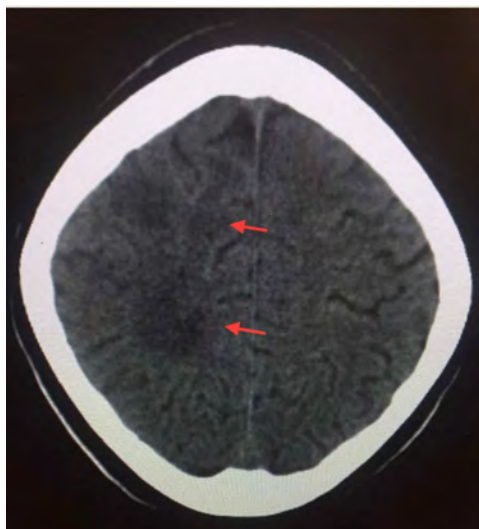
CT brain non contrast demonstrating hypo densities in right superior fronto-parietal region.
